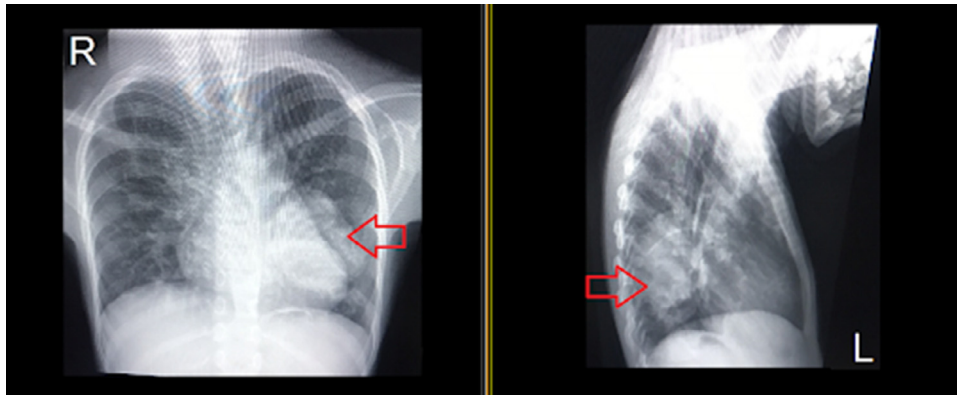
Follow-up after 3 months chest X-ray showing slight regression in size of the RA.
